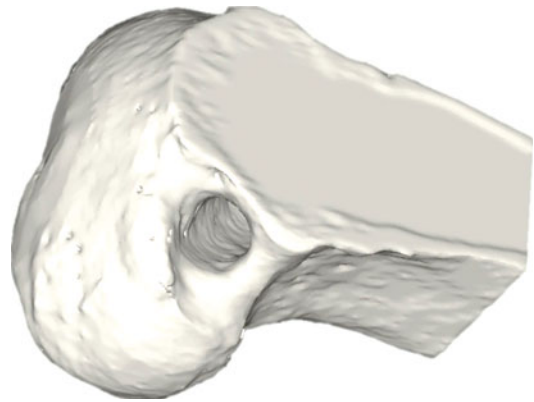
3D CT reconstruction: femoral nonanatomic tunnel placement after traditional SB reconstruction technique with typical “high AM” tunnel placement
